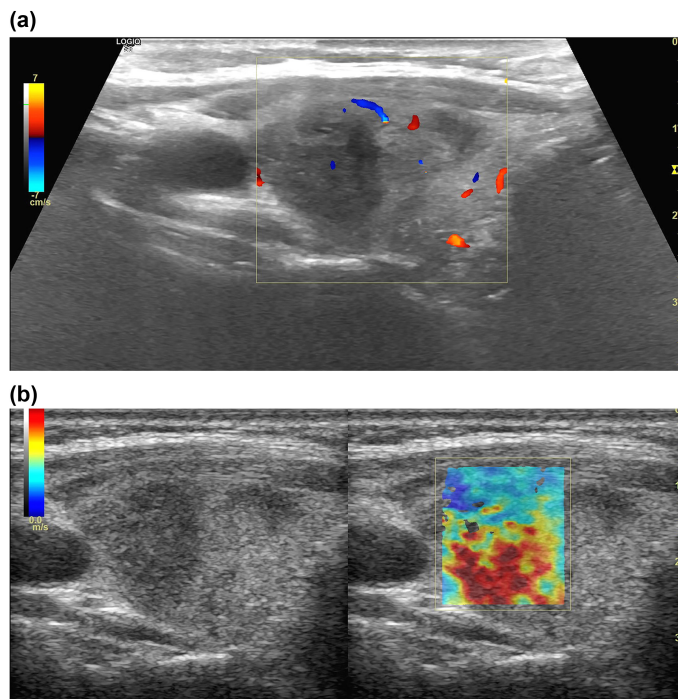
(A) In a case with a diagnosis of subacute thyroiditis, in the lateral part of the right lobe of the thyroid gland, color Doppler sonography shows a hypovascularized, patchy, heterogeneous, hypoechoic area. (B) In shear wave elastography evaluation, markedly increased velocity values and hard color coding (red) are observed in the area.
